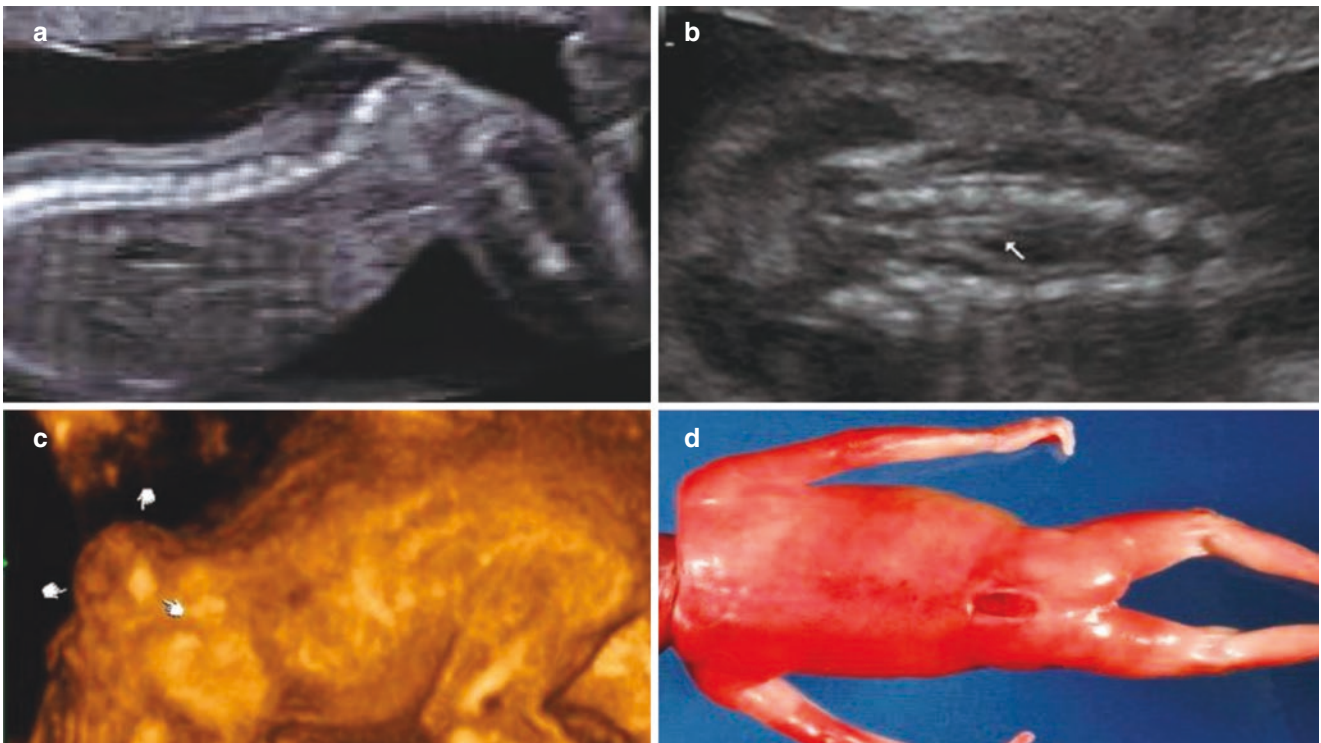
Spine bifida with meningocele II. (a–d). Prenatal ultrasound performance and images after labor
